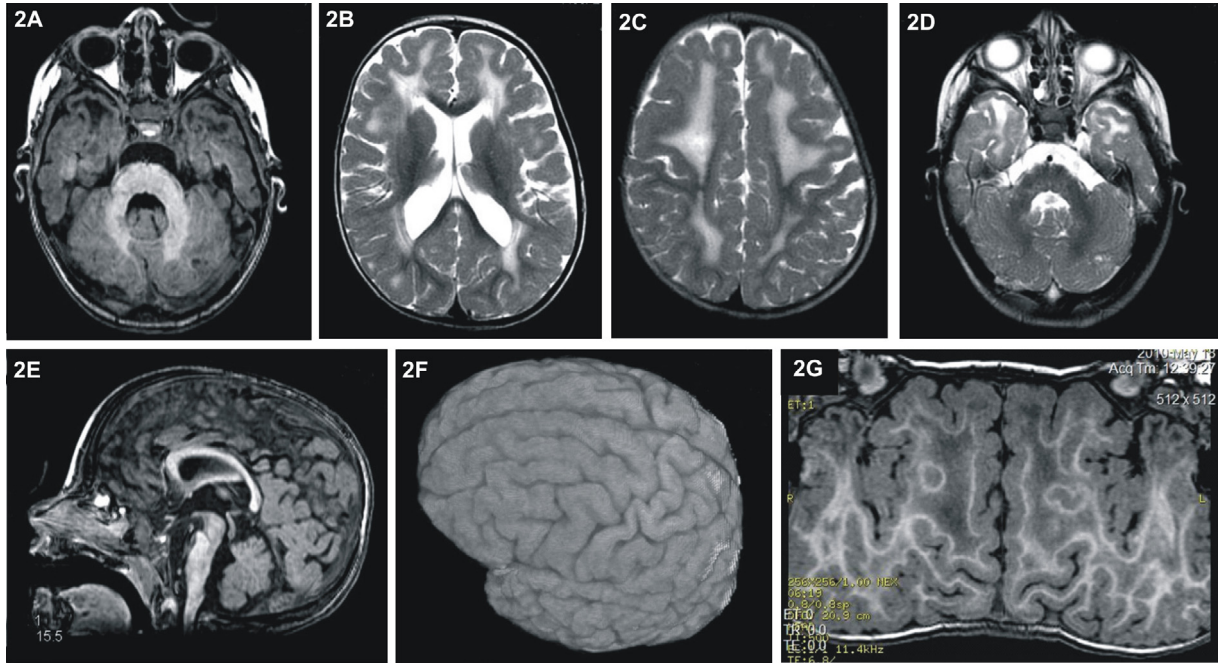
Central nervous system MRI. Axial T1- cerebellar microcysts suggesting cerebellar dysplasia (A); Axial T2-diffuse white matter hypersignal, diffuse polymicrogyria with anterior predominance (B, C); Axial T2-cortical cerebellar microcysts (D); Sagittal T1-moderate protuberance (E); Reconstruction 3D, curv – anterior cobblestone; white matter fronto-parietal and temporal hyposignal, preserving the subcortical fibers (F, G).
